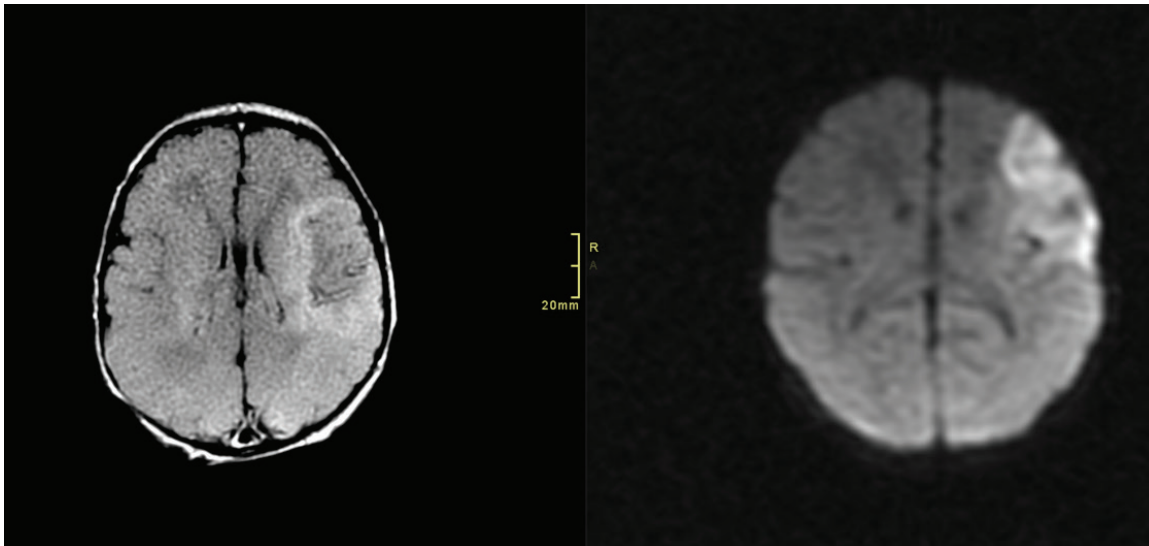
Ischaemic stroke in the left middle cerebral artery; left T2 FLAIR, right DWI sequence.
